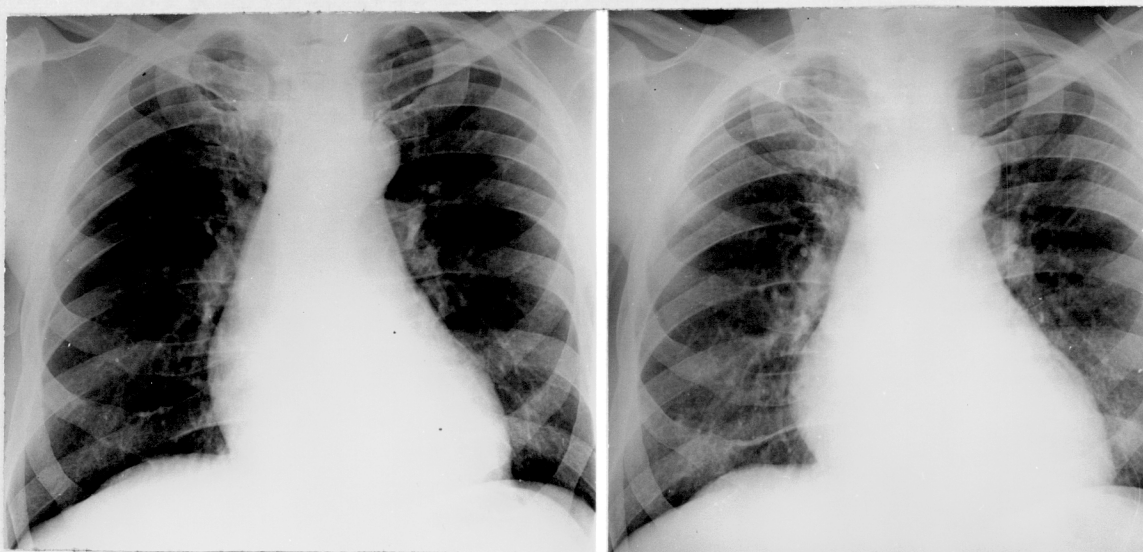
Chest radiograph of Patient number 138, in atrial fibrillation on the left, and sinus rhythm on the right. The CTR is 48% in atrial fibrillation and 53% in sinus rhythm.
